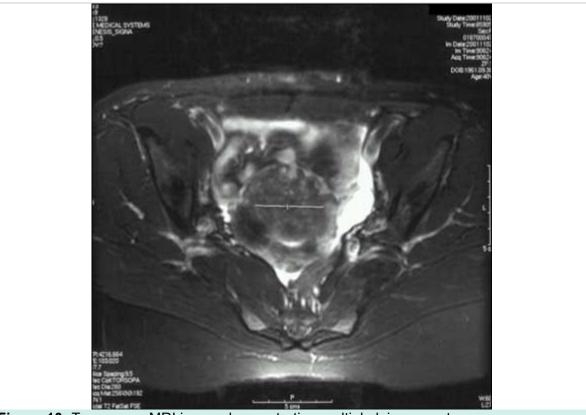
Transverse MRI image demonstrating multiple leiomyomata.
